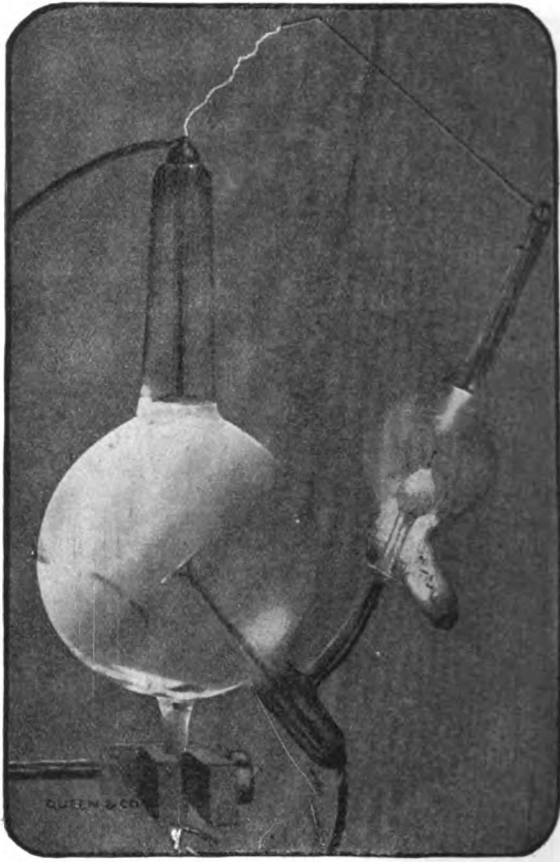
The Queen self-regulating x-ray tube.
